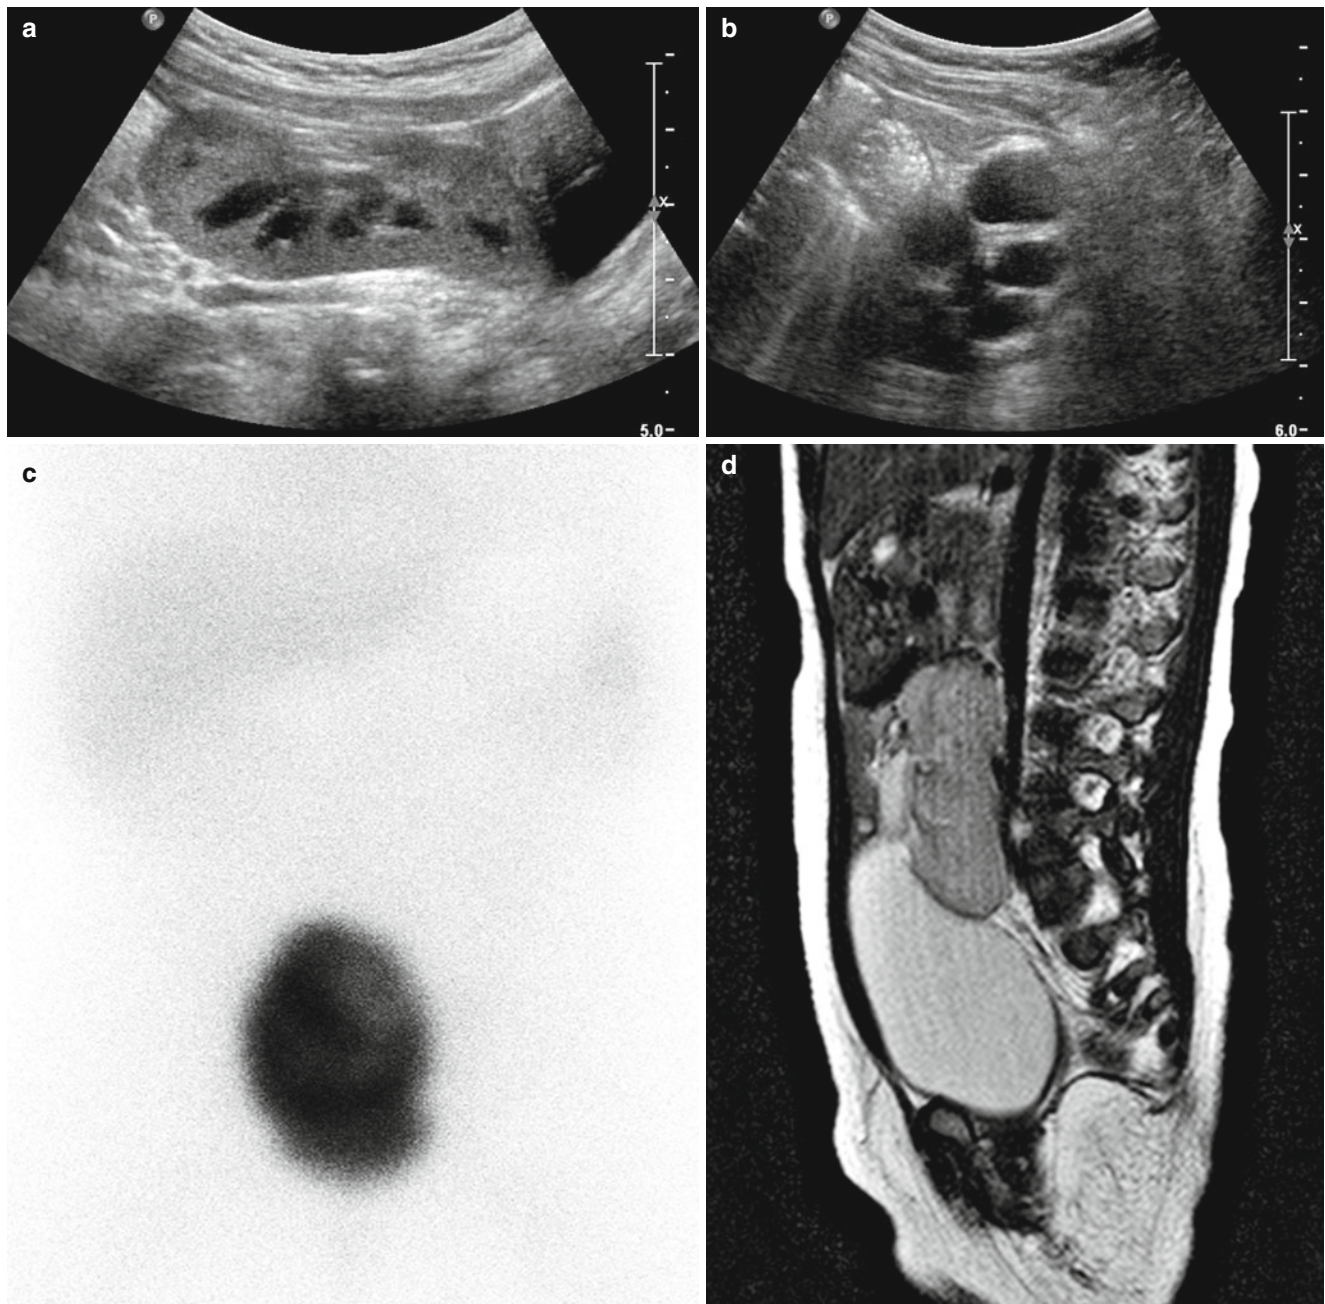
Pelvic kidney in a 1-year-old boy. (a) Abdominal US shows hypertrophied right kidney in pelvic cavity just above urinary bladder with anterior position of renal pelvis. (b) Abdominal US of left renal fossa shows multicystic dysplastic left kidney. (c) Tc-99 m DMSA scan shows only uptake in the pelvic kidney. (d) T2-weighted sagittal MR
